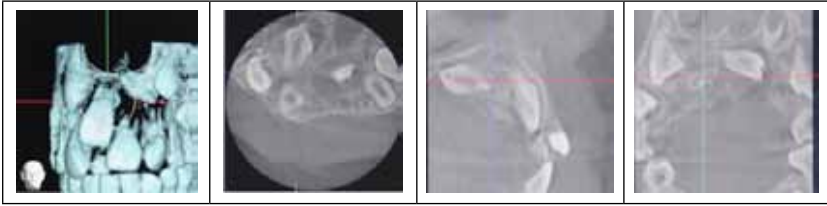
A CBCT images showing unerupted maxillary left central incisor (Photo credit: Raja Zarina Raja Shahardin)
